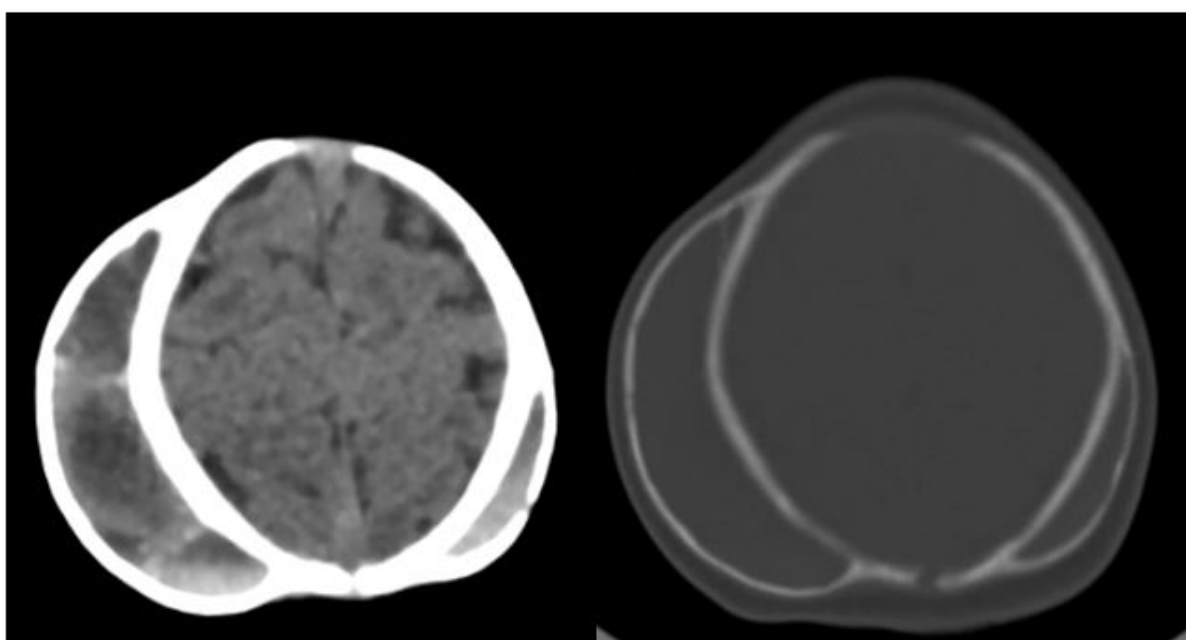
Axial sections of non-contrast CT scan of the head shows biparietal hypodense swellings with ossified outer layer. Few hyperdense contents are seen within. The underlying calvaria appears normal.
